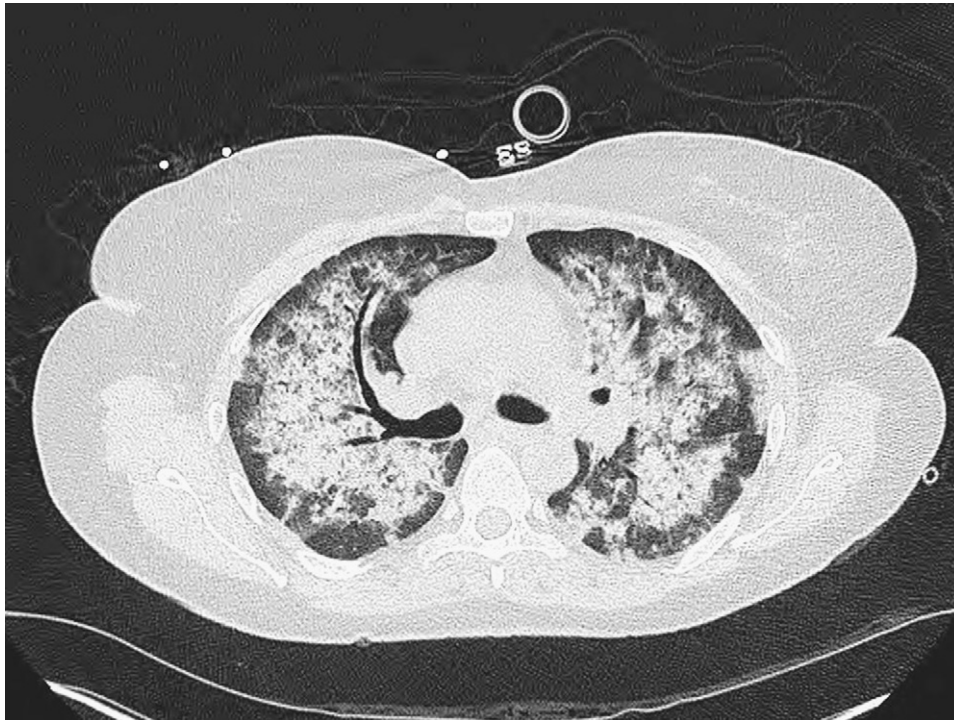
Computed tomographic scan demonstrating bilateral ground-glass infiltrates from alveolar hemorrhage as can occur in WG or MPA.
